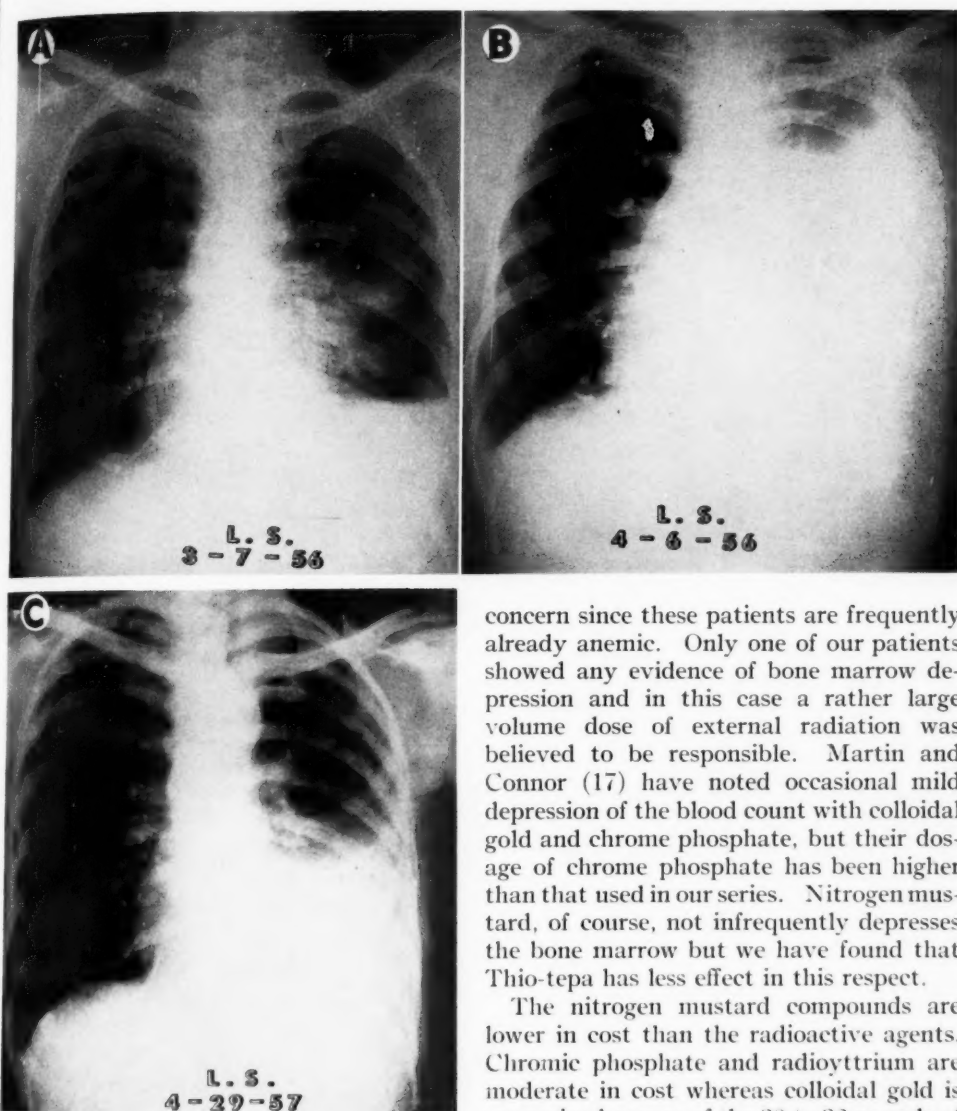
Case 1. A. Chest roentgenograms made on March 7, 1956, six days after thoracentesis and instillation of chrome phosphate.
